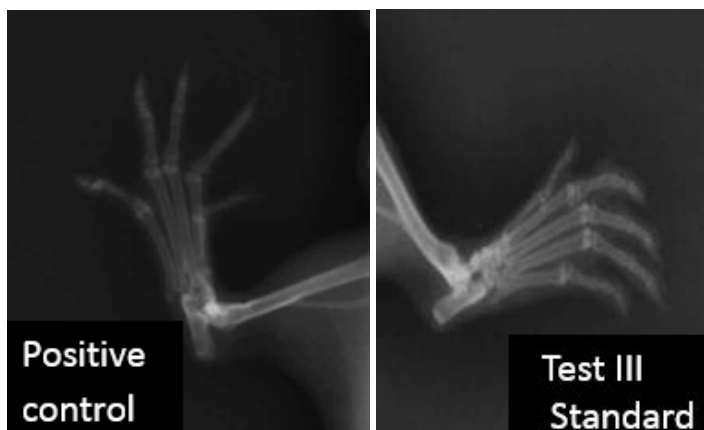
Radiographs taken after completion of study period
